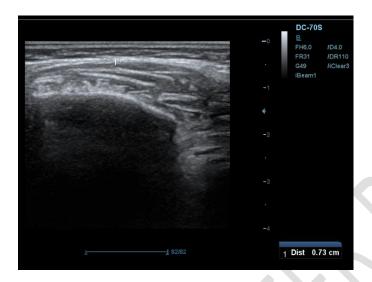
Ultrasonography of geniohyoid muscle
